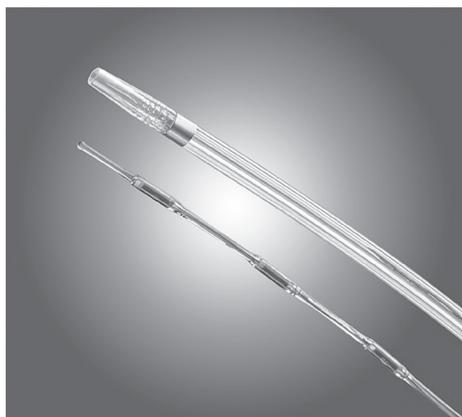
The transducer tipped ultrasound probe of the EKOS EndoWave Endovascular Device. (Kindly provided by EKOS Corporation, Bothell, WA, USA)
